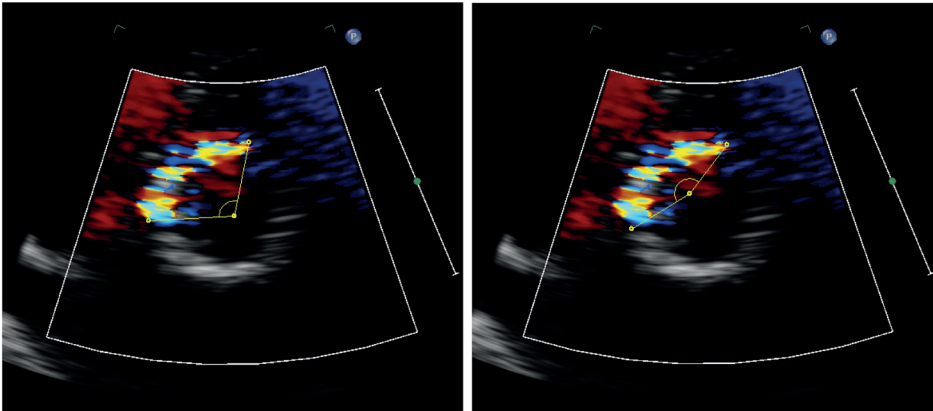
Potential overestimation of PVL with iRotate echocardiography. Correct imaging around the central axis gives a PVL circumferential extent of 105° (left) versus 160° with incorrect imaging (right).
